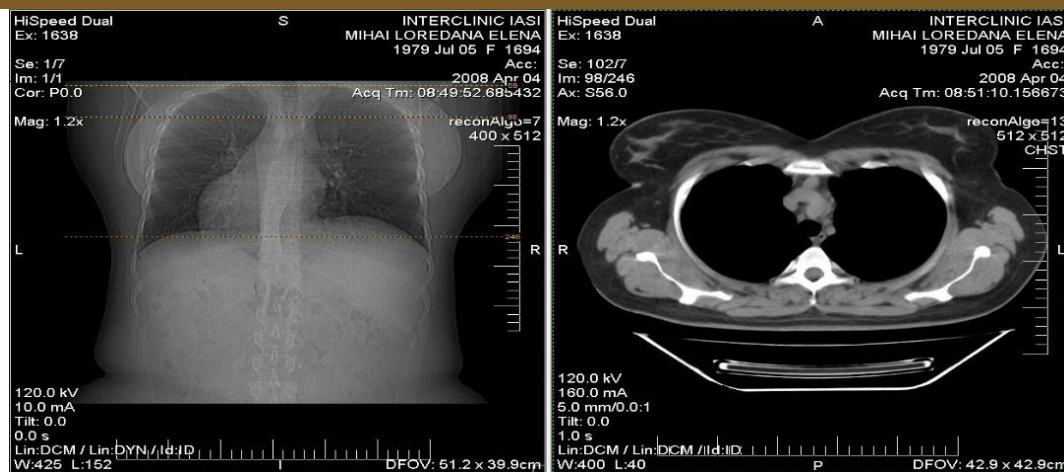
Thorax CT showing enlarged heterogenous thymic gland.
